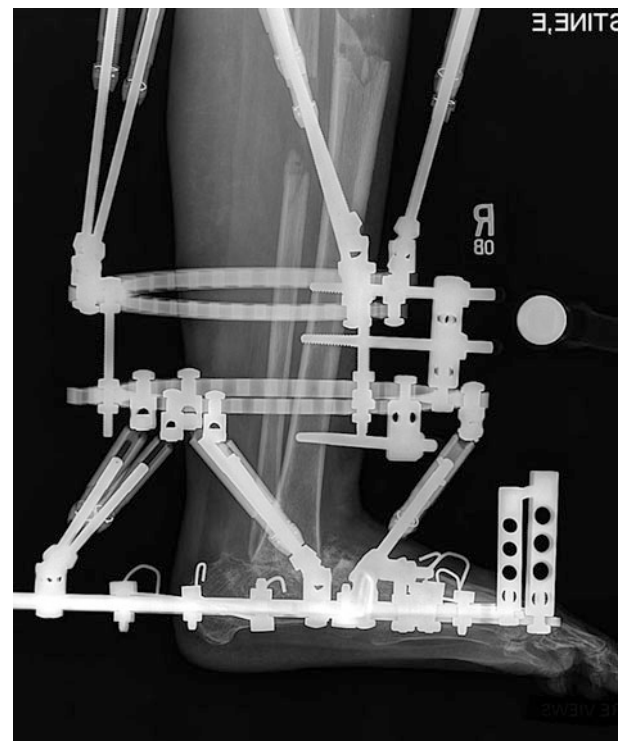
ED radiograph showing ankle fusion stabilized by TSF
